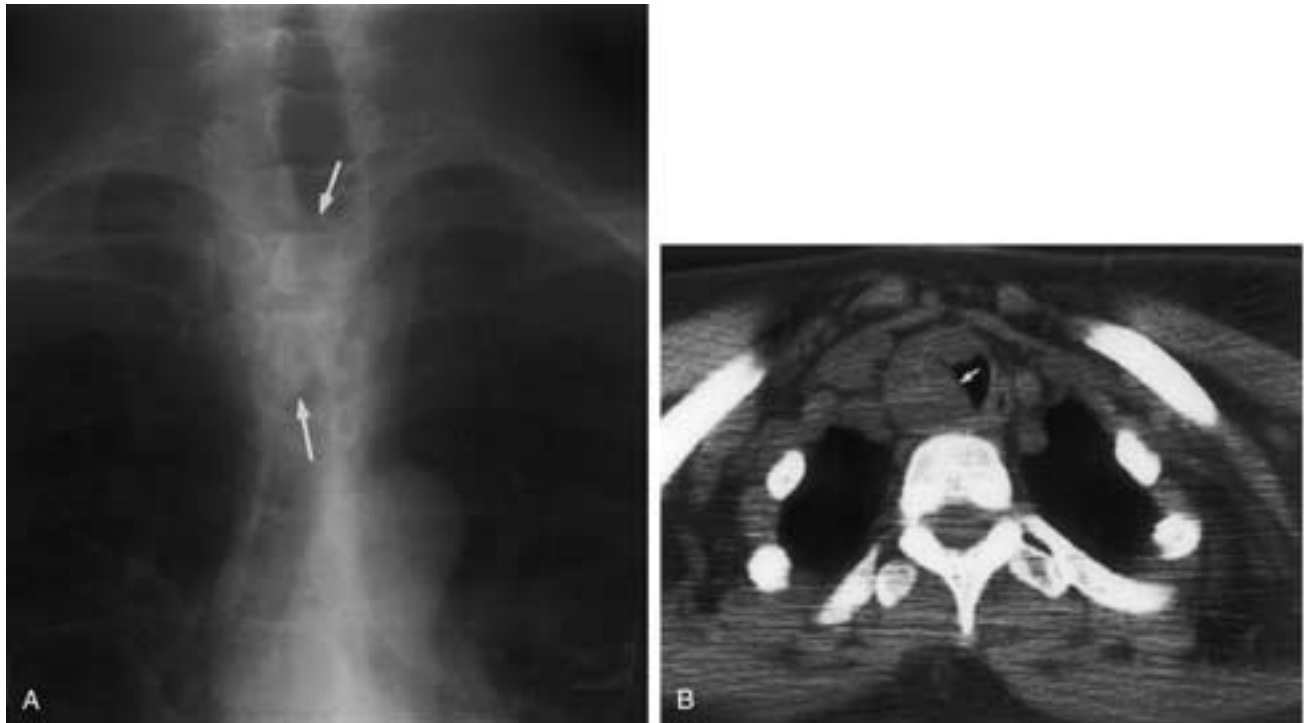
Adenoid cystic carcinoma. A, Chest radiograph demonstrates a large, broad-based endoluminal mass arising from the right tracheal wall (*arrows*) and partially obstructing the tracheal lumen. B, Axial nonenhanced CT scan demonstrates this large, lobulated, low-attenuation endoluminal mass arising from the right tracheal wall at the level of the thoracic inlet (*arrow*). Tumor is seen along the outer wall of the calcified cartilage as well, indicating infiltration either through or between the tracheal cartilages.
